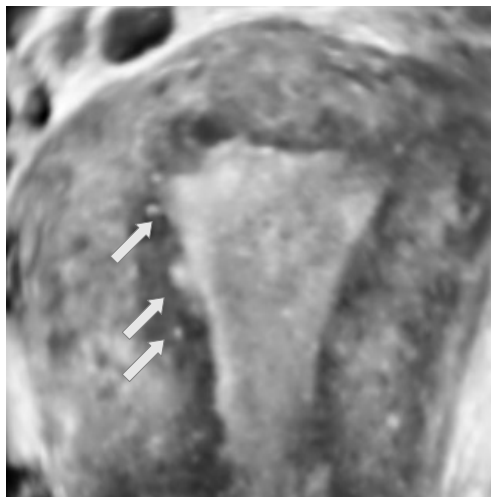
3D ultrasound showing an irregular internal myometrium covered by hyperechoic bands originating from the endometrium (arrows)
